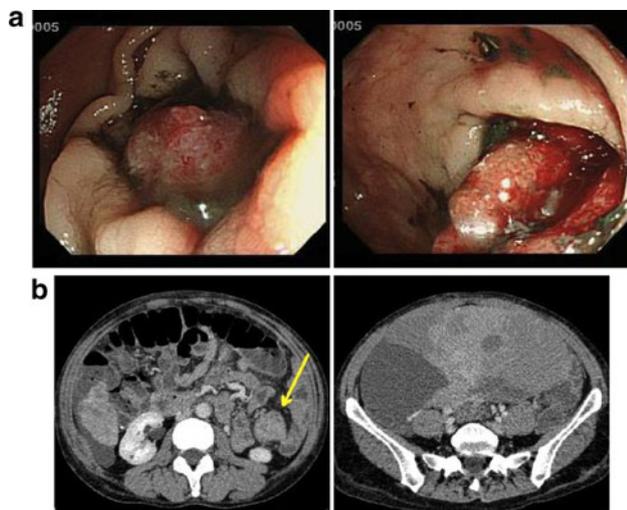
Colonoscopy and CT images 2 months after onset. a Captured images during colonoscopy. Compared with Fig. 1c, the tumor had grown so rapidly that the lumen was subtotally occluded. b CT images of the colon and pelvic tumors. *Left panel* Upper colon from the stenosis site at the sigmoid with a massive tumor is enlarged. *Arrow* indicates the lesion. *Right panel* Pelvic tumor is also extremely increased in size compared with that in the former images
